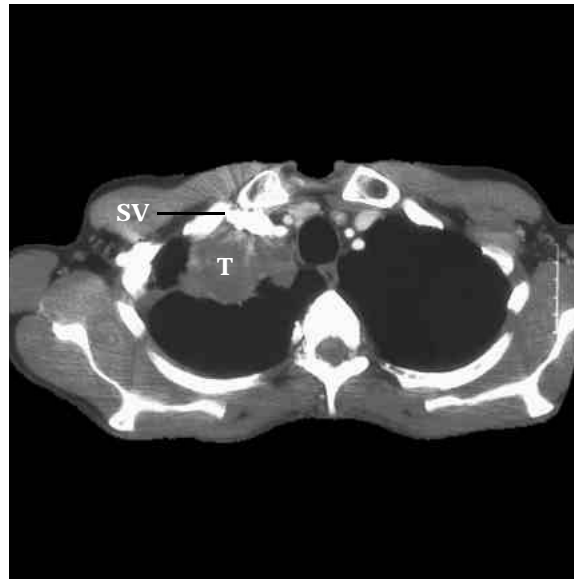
LUNG TUMOR CT image. Cancerous lung tumor in a person who chronically smoked. The tumor has partially occluded the subclavian vein (SV), which is filled with contrast medium.
